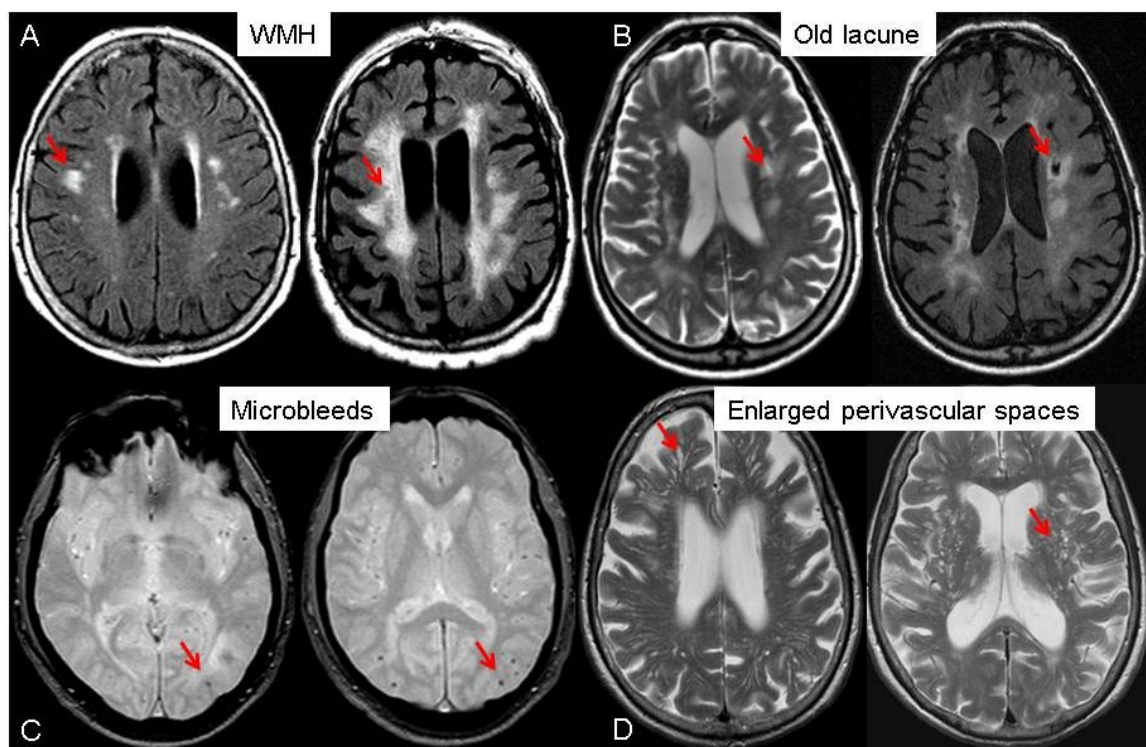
Hallmarks of chronic cerebral small vessel disease (A-D) on MRI. (12)
